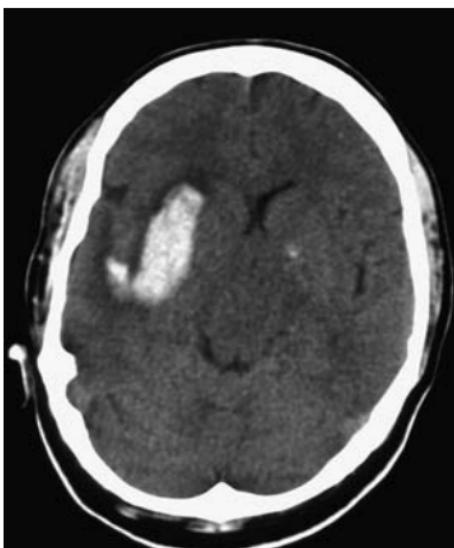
Primary hypertensive haemorrhage (non-enhanced CT). Typical ganglionic haematoma with acute haemorrhage involving the right lentiform nucleus and minor extension into the insular cortex. There is slight effacement of the ipsilateral frontal horn and Sylvian fissure.
